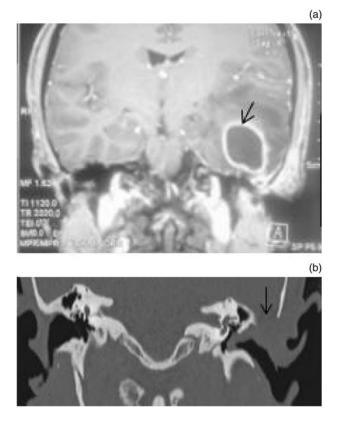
(a) Contrast enhanced MRI scan of the brain (coronal cut) showing a large temporal lobe abscess with enhancing wall (arrow) and surrounding brain oedema. (b) High-resolution computed tomography scan of the temporal bone showing a large defect of the tegmen (arrow).
